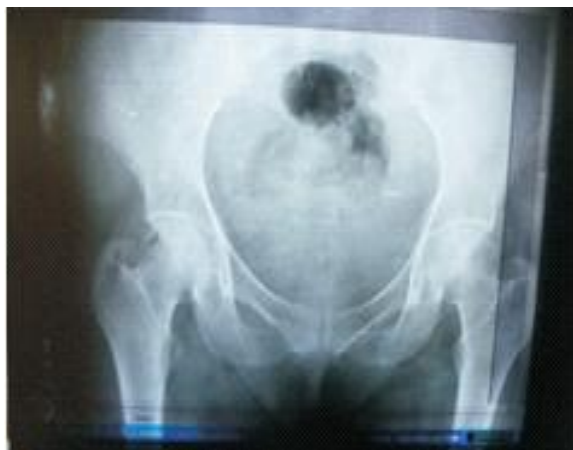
Case 1 X-Ray showed a calcified mass in the subcutaneous plain not attached to the underlying bone.
